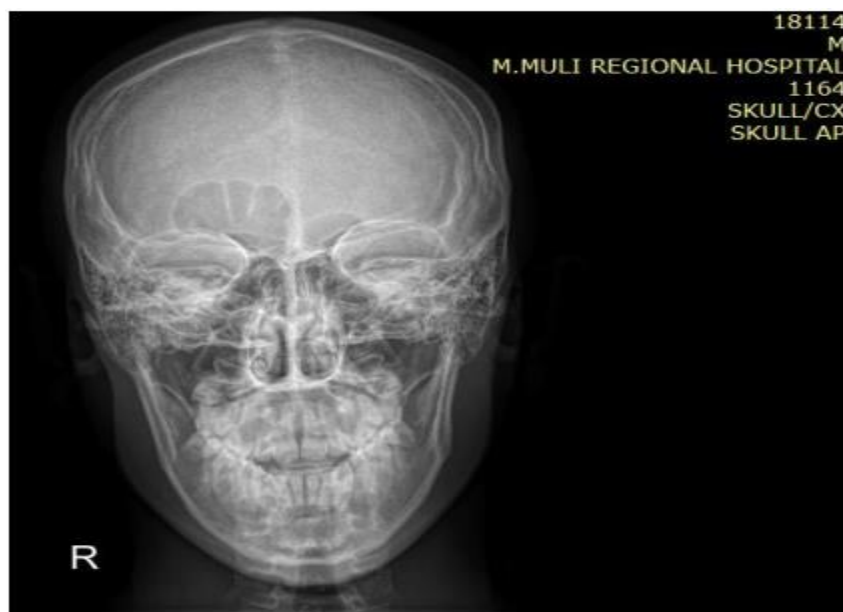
Normal X-ray skull of patient presented with head trauma; skull X-ray was the least conclusive study as it has a limited role in assessment of head trauma (only discovering skull fractures). Patient was transmitted to another hospital and had CT scan, which approved that he has an extradural hematoma.
